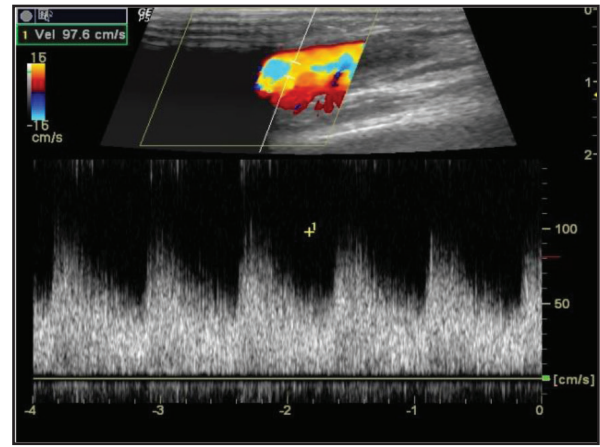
Post-angioplasty Doppler image showing adequate low resistance flow in draining vein.
